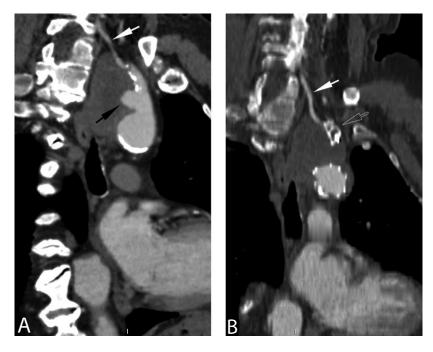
Coronal multiplanar reformatted computed tomography angiography (*CTA*) images of a large left subclavian artery aneurysm (*black arrow*) before (A) and after (B) stent graft deployment followed by transbrachial deployment of an occluder plug (*empty arrow*) proximal to the left vertebral artery (*white arrow*).
